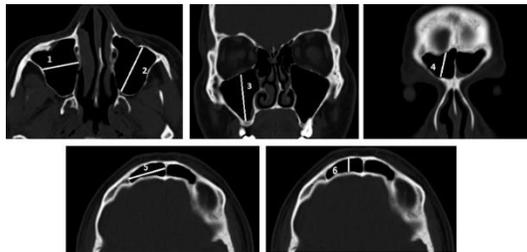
CT axial and coronal image showing the measurement of different dimension. (1) Width of maxillary sinus (2) antero-posterior diameter of maxillary sinus (3) cranio-caudal diameter of maxillary sinus (4) cranio-caudal diameter of frontal sinus (5) Width of frontal sinus (6) antero-posterior diameter of frontal sinus.
